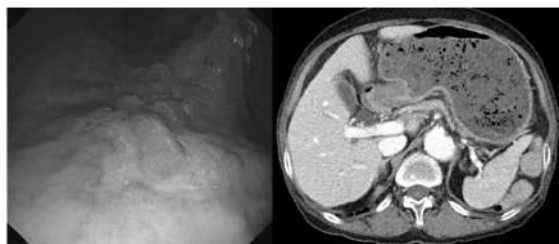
Upper endoscopy and computed tomography findings.
